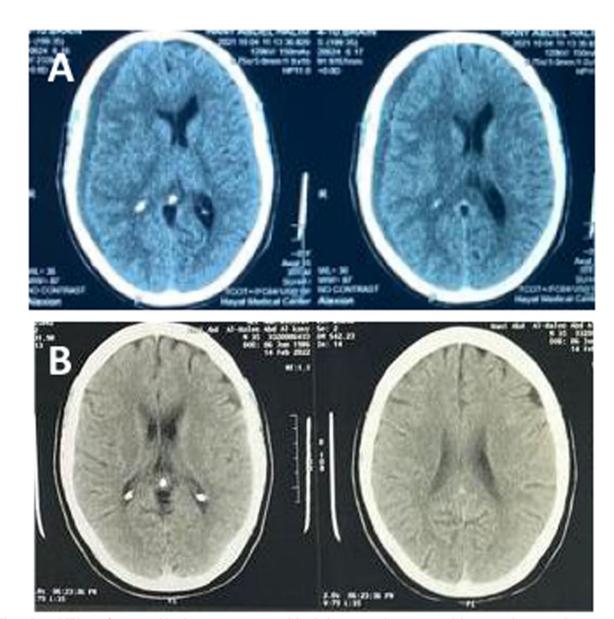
A Initial CT brain of a 59-year-old male (formerly having a bilateral ventriculo-peritoneal shunts) presenting with depressed level of consciousness and hemiparesis, showing a left frontal unilateral CSDH producing midline shift. Dexamethasone treatment was initiated. B Complete resolution of the CSDH after 4 months follow-up
